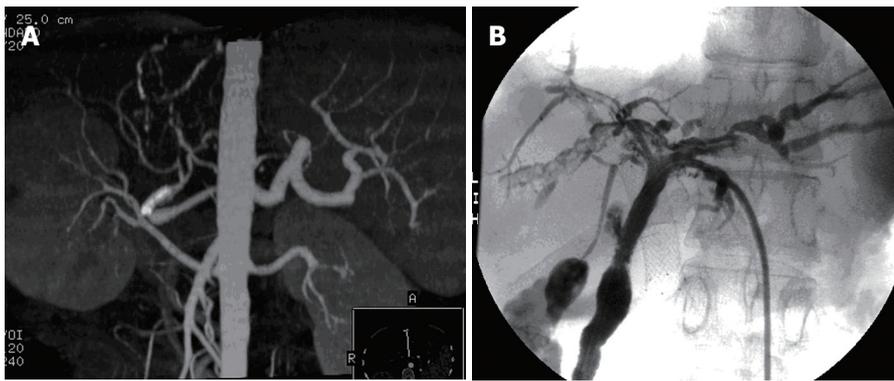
Images pertaining to case 3. HAS was diagnosed 4 d after OLT, and coronary artery stent placement was performed. Diffuse intra- and extra-hepatic bile duct stricture was apparent 10 mo after OLT. PTBD, balloon dilation and bile duct stent placement therapy were performed. A: Computed tomography angiography revealing HAS disappearance following HA stent placement; B: Cholangiography showing bile duct stiffness, rare branching, and filling defect in the bile duct lumina.
